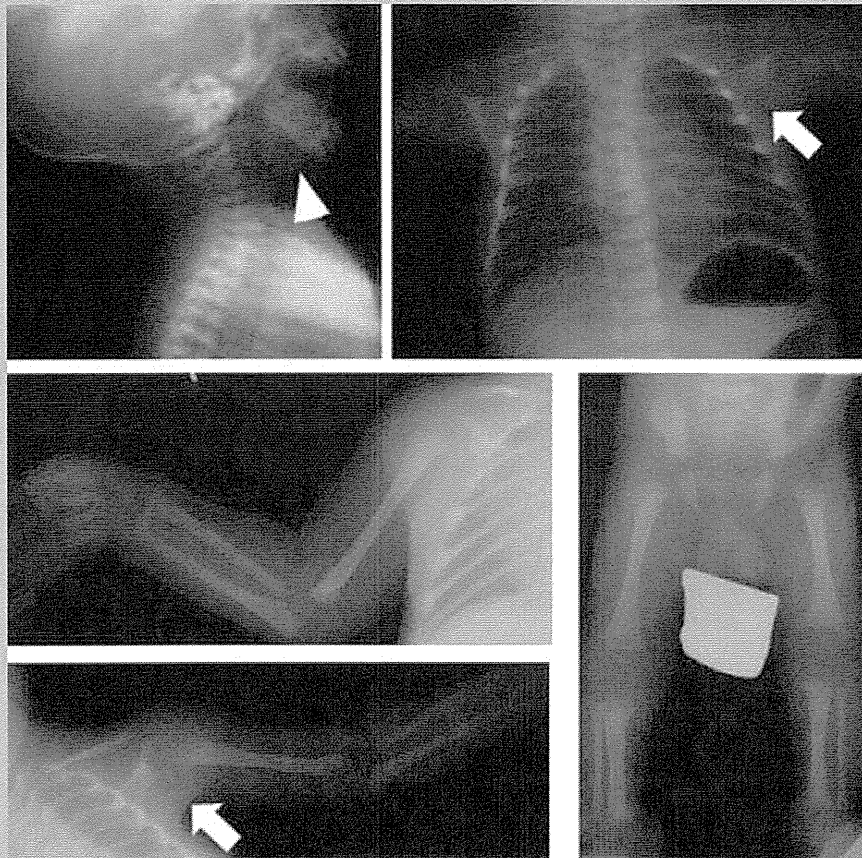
Roentgenograms of the patient at 2 weeks of age. Mild hypoplasia of left scapula (white arrows) and micrognathia (a white arrowhead) are indicated.
